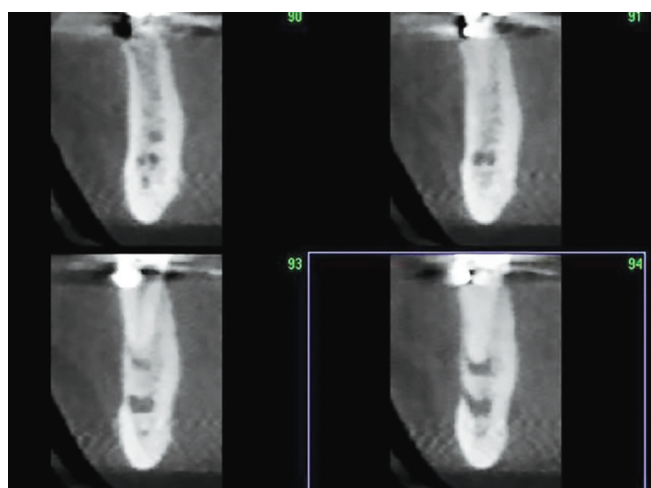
Intermediate-implant bone density on CBCT
